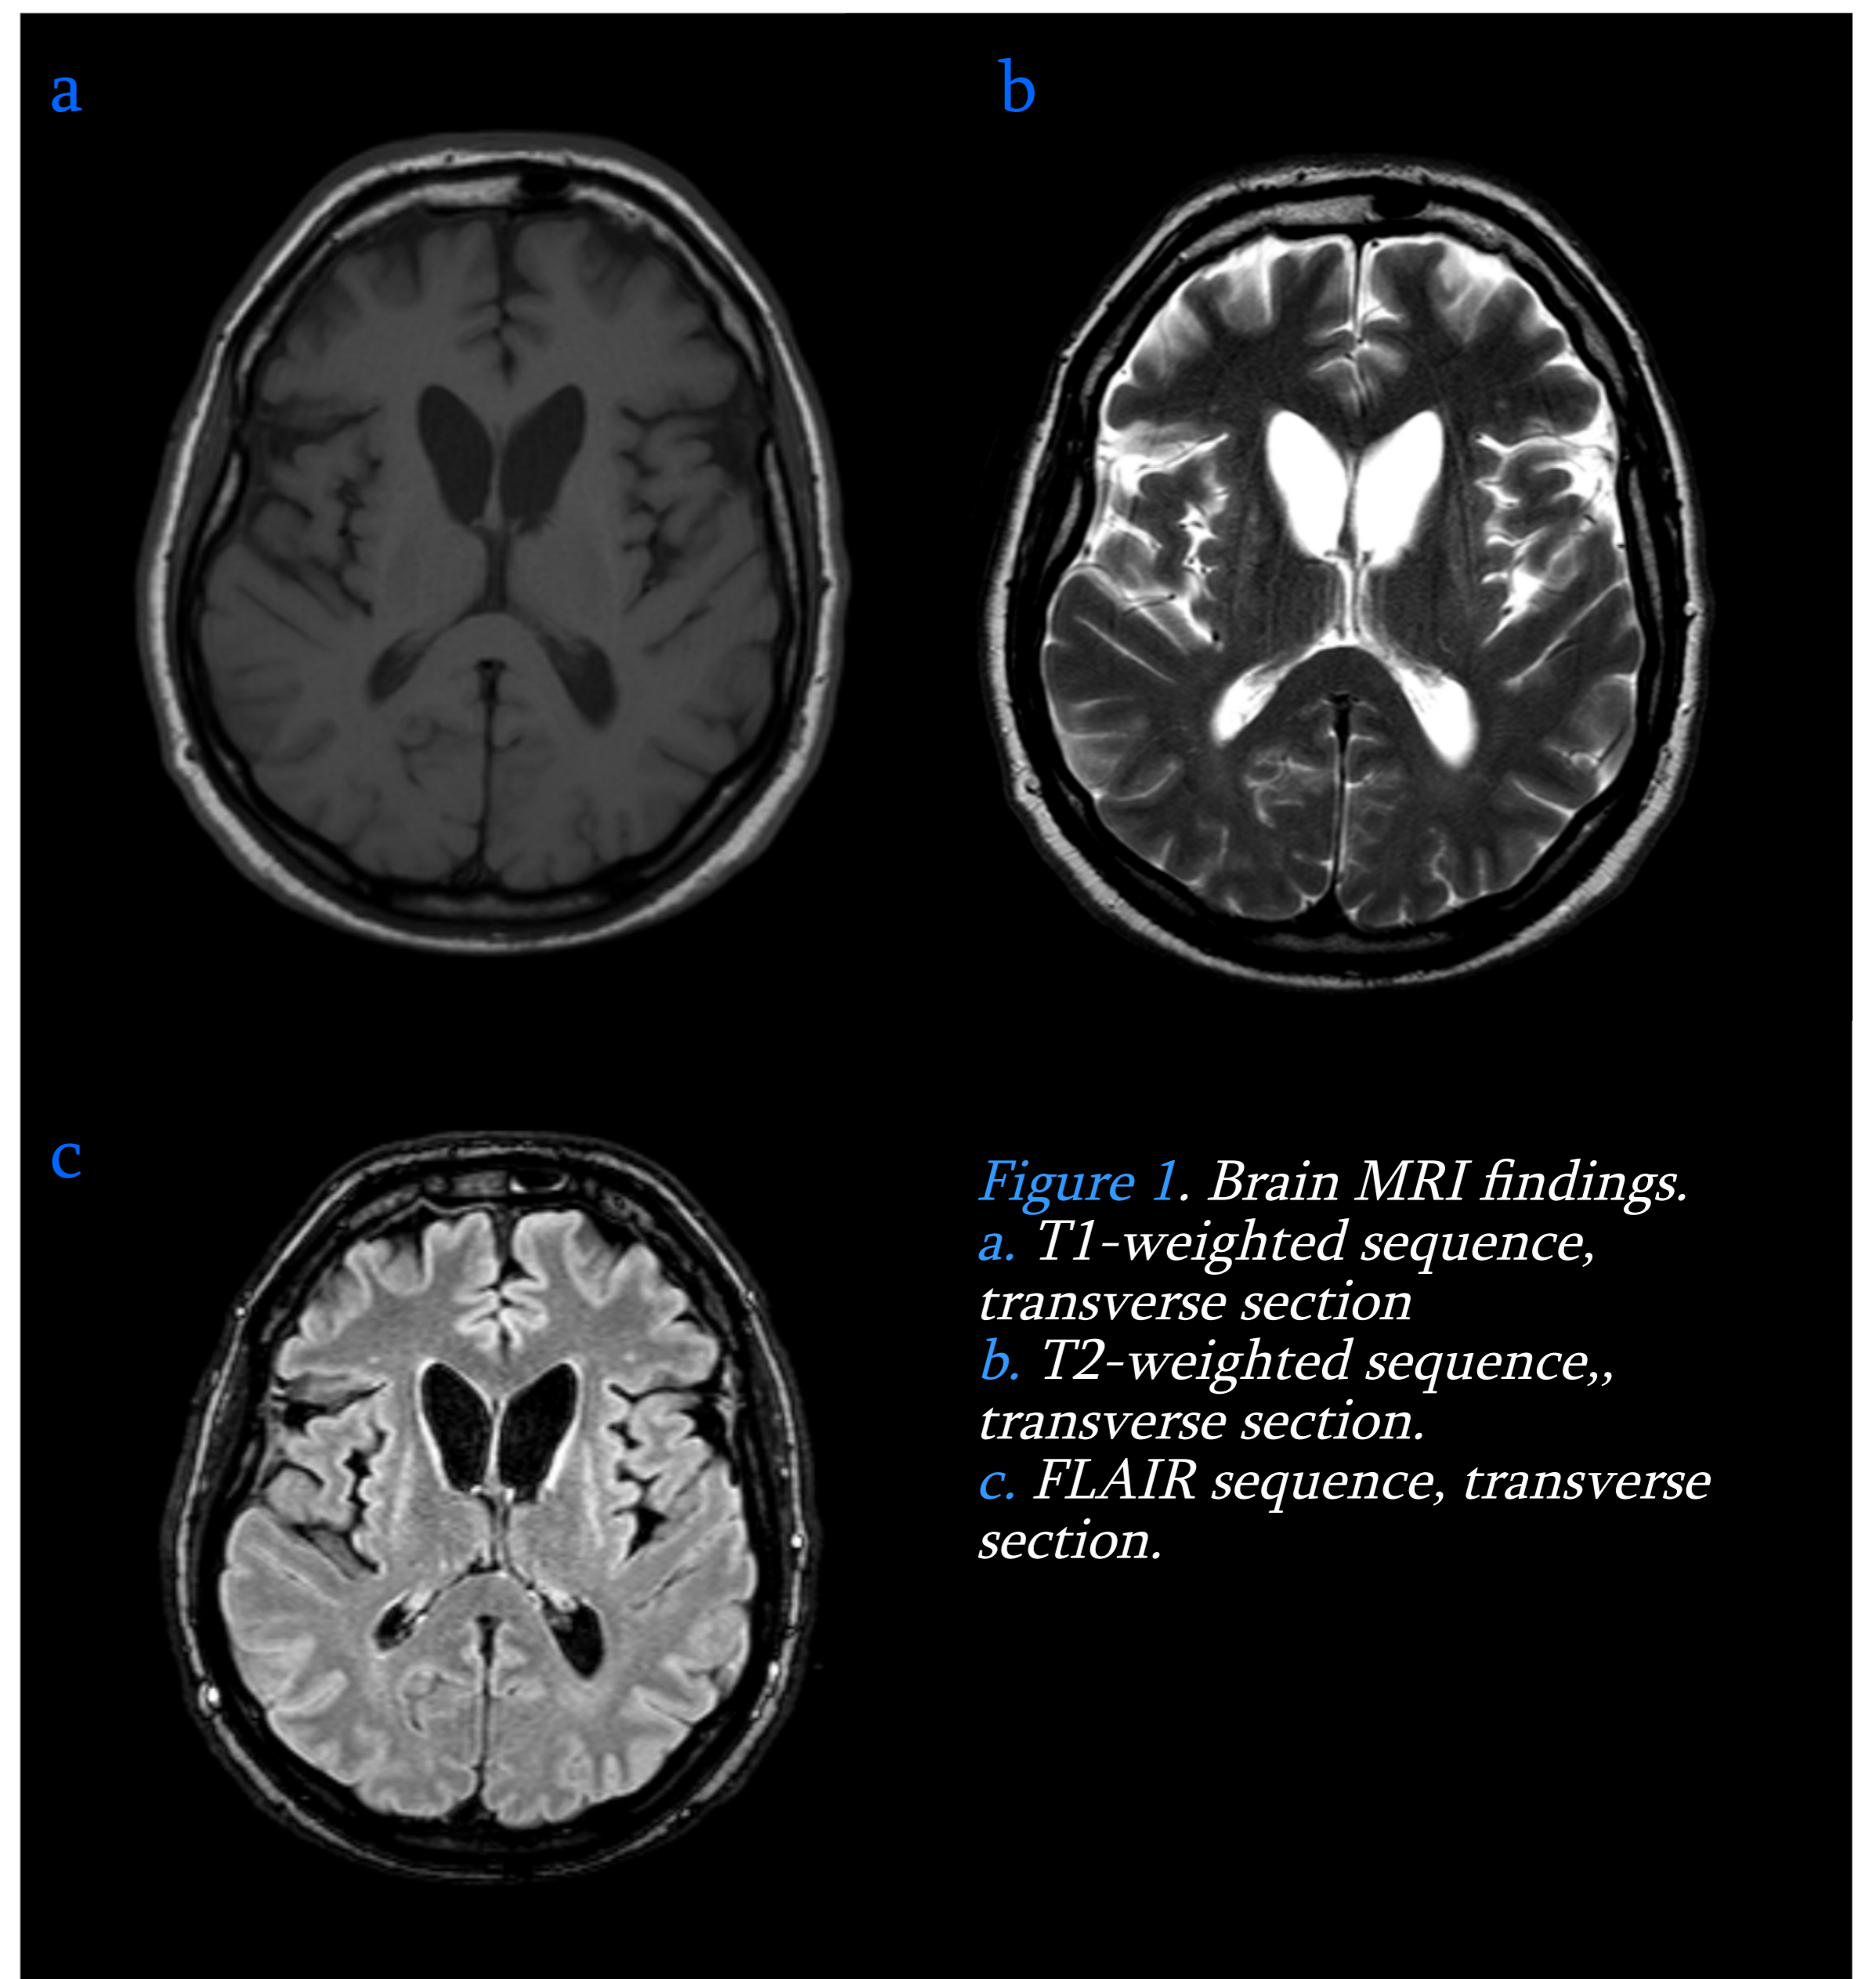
Brain MRI findings.
